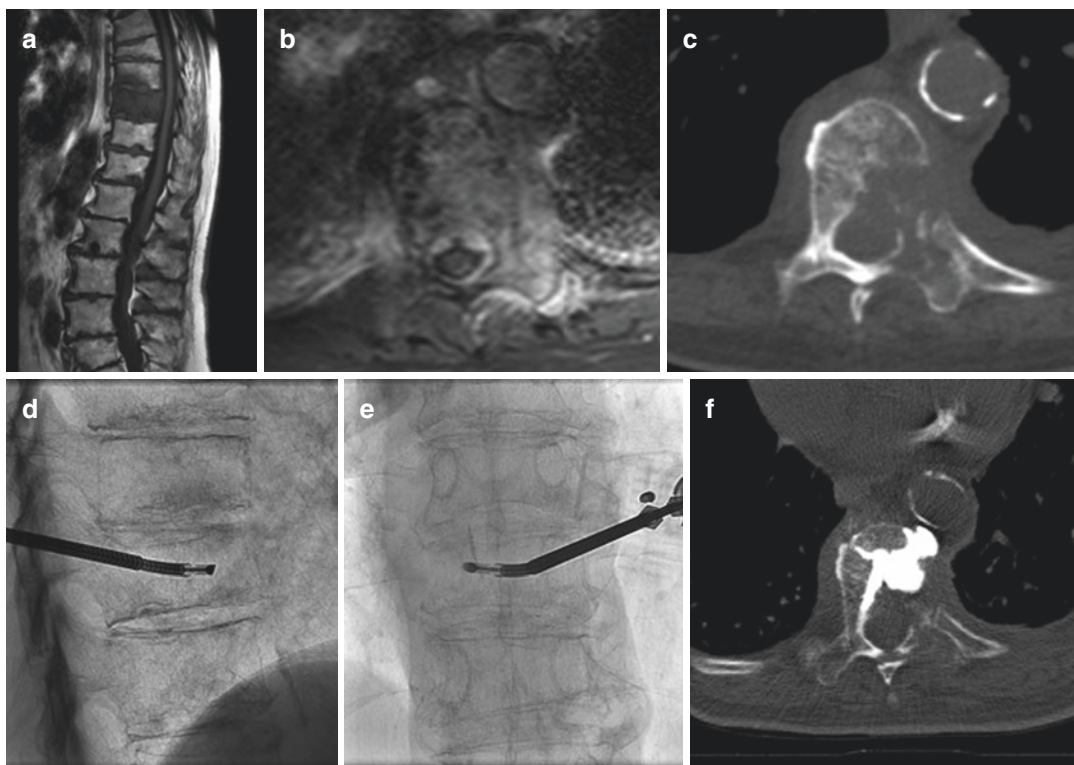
84 year old women with metastatic adenocarcinoma of the lung. (a) is a sagittal T1-weighted images showing abnormal low signal intensity of T10 and inferior end-plate of T9. (b) and (c), Axial enhanced T1-weighted image with fat suppression at T10 level (b) showing an enhancing lesion in the left side of the vertebral body extending into the left pedicle with small epidural extension. A corresponding cortical disruption at the same level can be seen in CT image (c). (d) and (e), Radiofrequency
